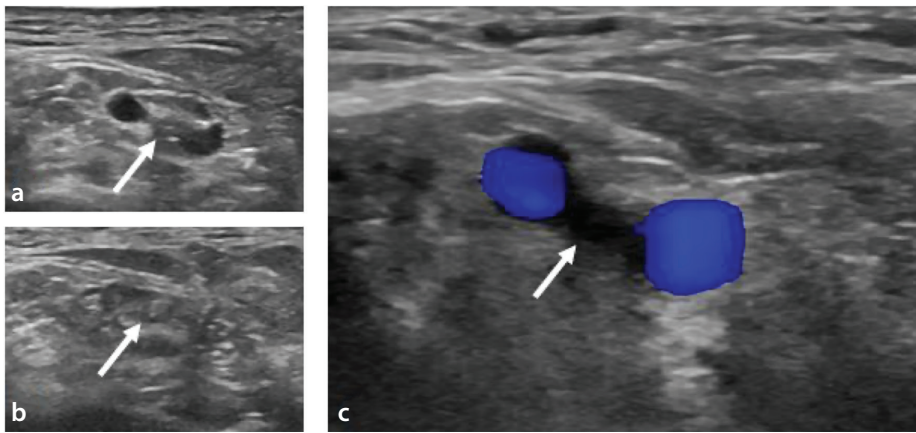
Ultrasound visualization of the occluded posterior tibial artery (PTA) with a linear high-frequency transducer placed transversely in a 46-year-old male patient with thromboangiitis obliterans. (a) The PTA (arrow) is seen at the center of the image between the posterior tibial veins. (b) The posterior tibial veins are compressed because of pressure applied with the transducer, whereas the PTA (arrow) cannot be compressed. (c) In color Doppler imaging, the venous flow can be observed, but there is no arterial flow, which reveals the presence of occlusion.
